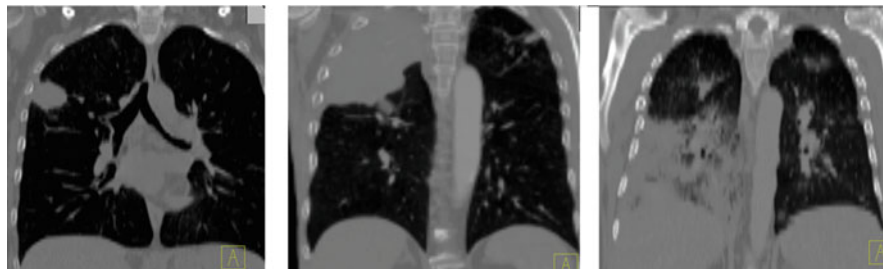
Examples of how diseases, such as tumors or interstitial lung disease, affect the appearance of lung in CT
